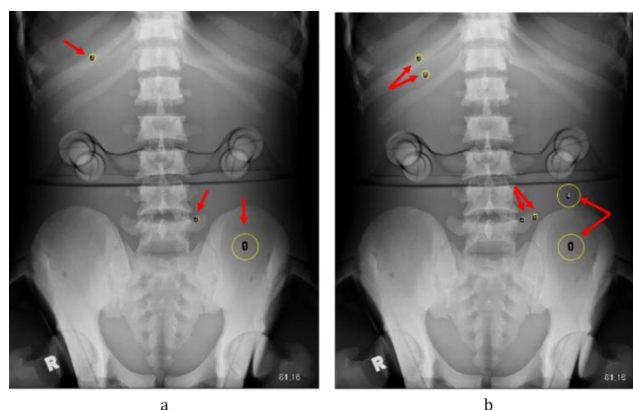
a) Three ROIs marked on the radiographs in ImageJ software to calculate the SNR. b) Another added three ROIs, placed adjacently to the previous ROI to calculate the CNR. The red arrow shows the ROI in the images.
